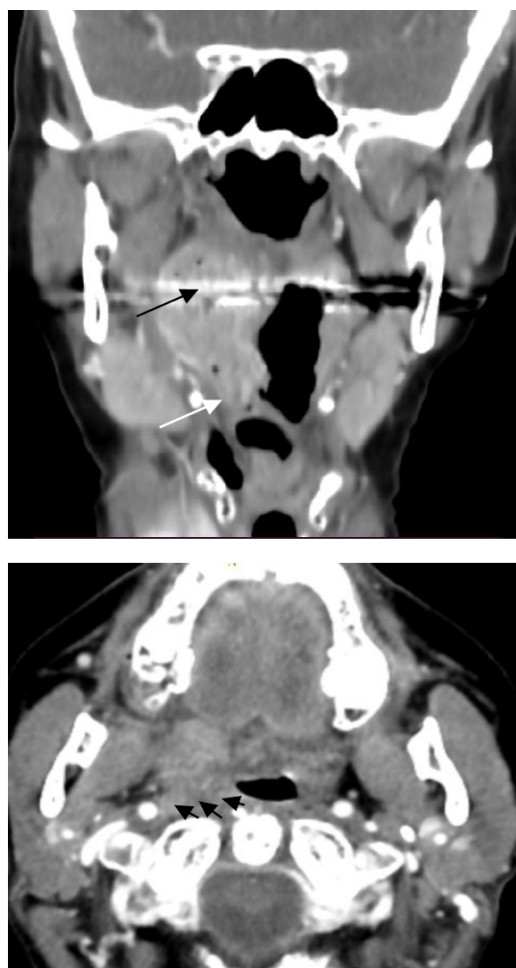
Squamous cell carcinoma of the soft palate a. coronal CT scan shows an enhancement mass of the soft palate (large black arrow) and demonstrates the tumoral spread into the right vallecula (large white arrow); b. axial contrast-enhanced CT image shows a soft palate tumor with invasion into parapharyngeal space and prevertebral space (small black arrows); the internal carotid artery encases the right side.
